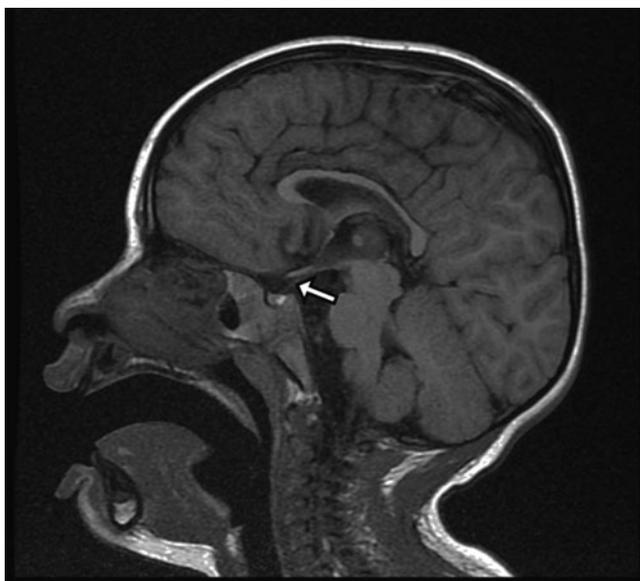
Sagittal T1-weighted MRI of a patient with a postfixed chiasm and significantly inclined pituitary stalk (*arrow*)
